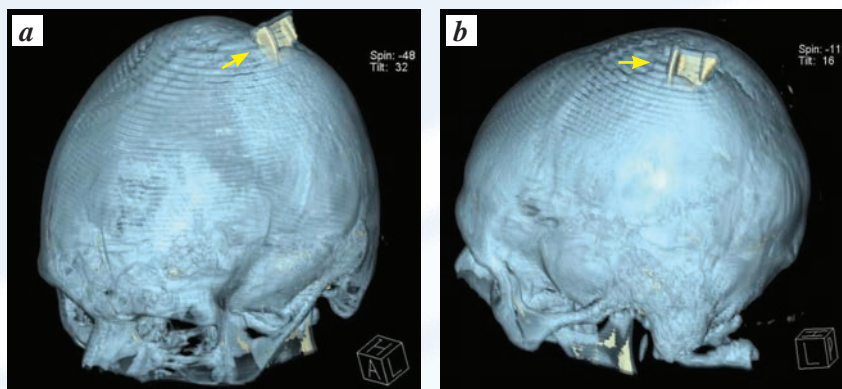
CT 3D reconstruction of skull: a – anterolateral; b – lateral. The metallic foreign body is shown by the white arrow.
